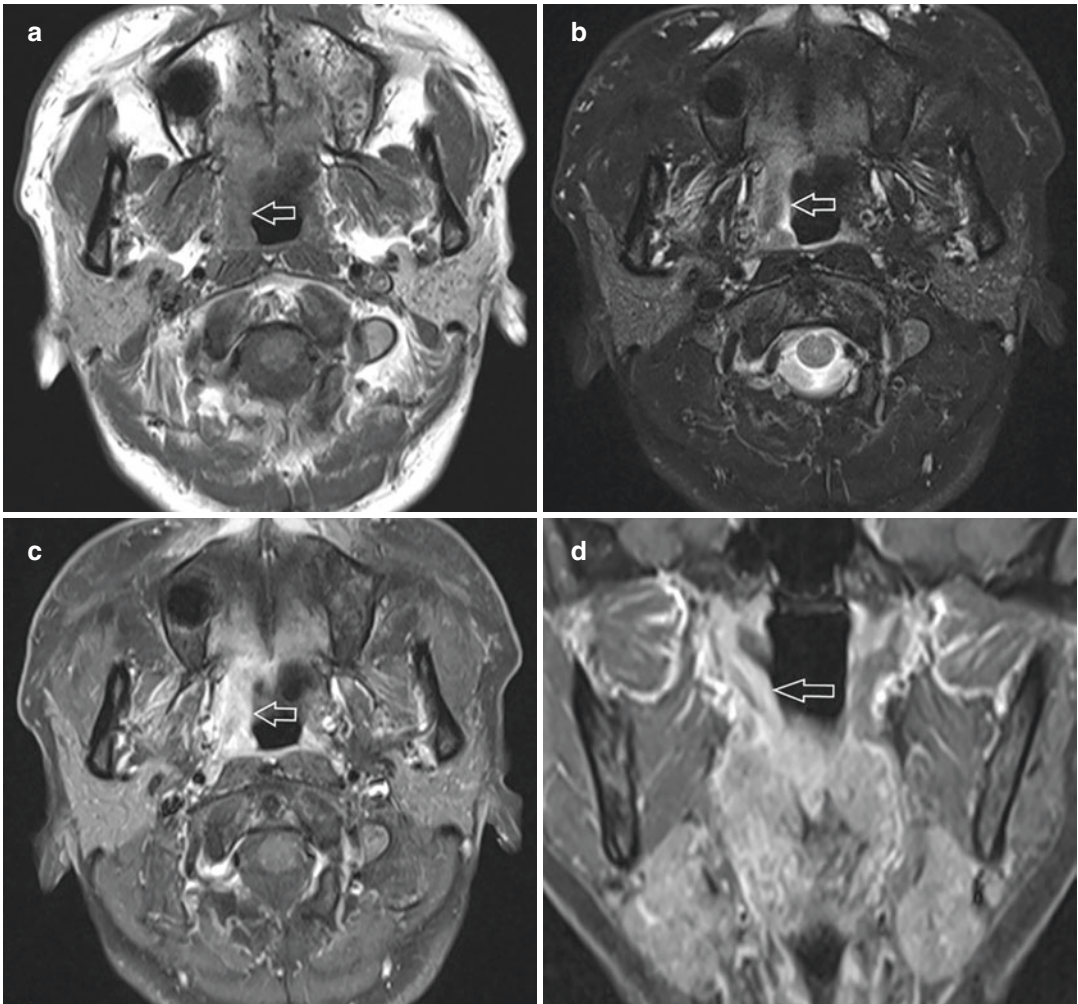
MRI of nasopharyngeal tuberculosis in a 43-year-old man who presented with right otitis media and right-sided hearing loss. Axial (a) T1-W and (b) fat-suppressed T2-W MR images show mucosal thickening at right lateral wall of nasopharynx which show isointense signal on T1-W and slightly hyperintense signal on T2-W
